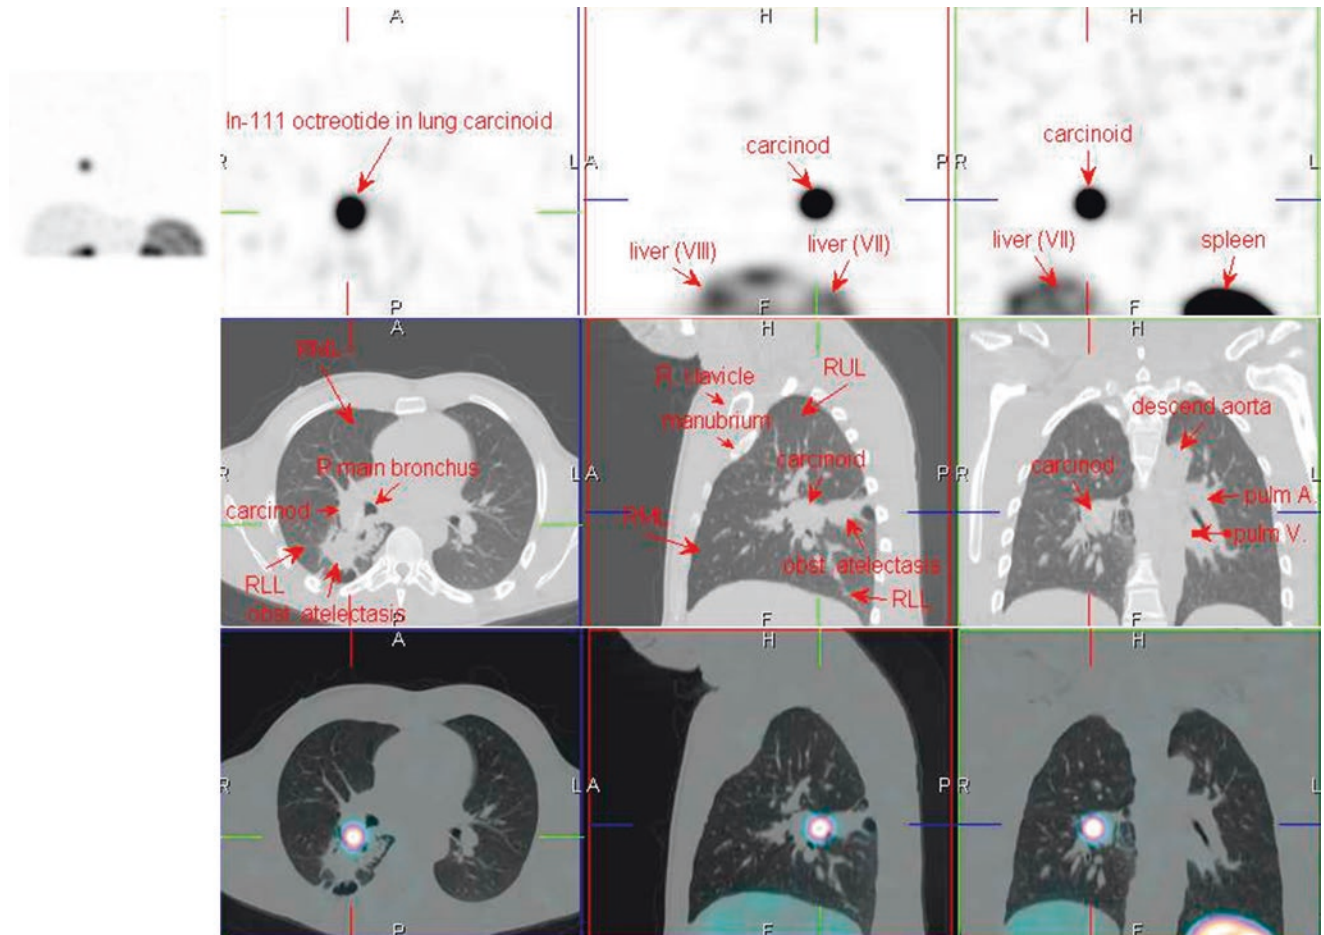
¹¹¹In-octreotide SPECT/CT
